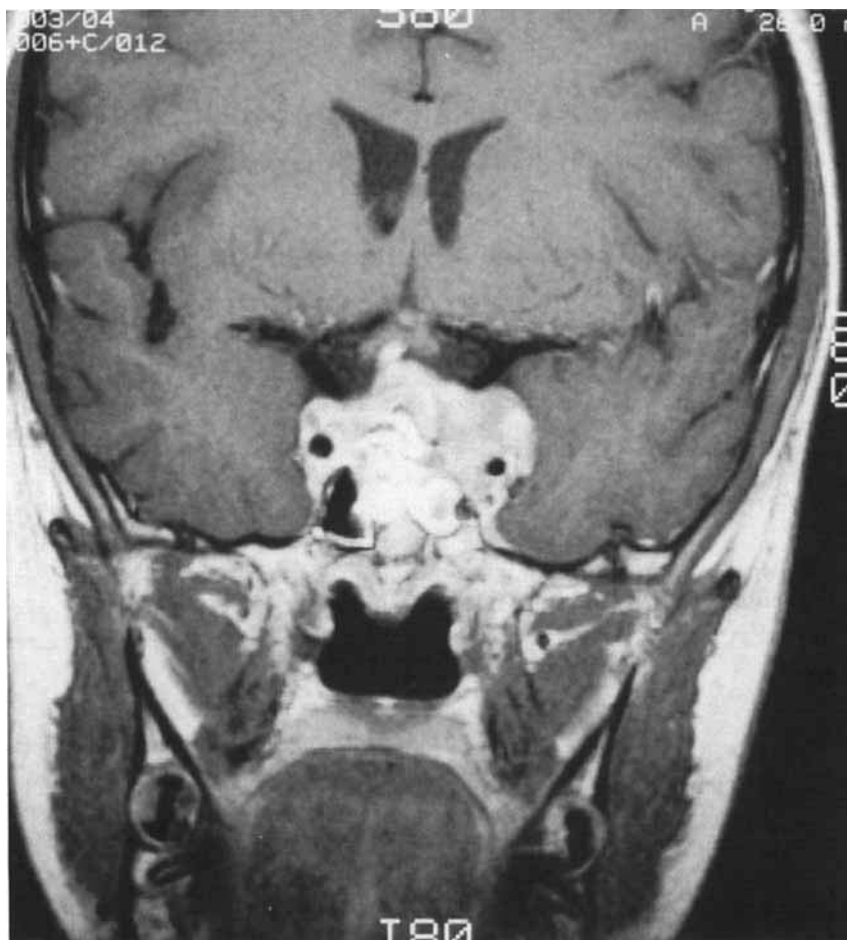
Magnetic resonance image demonstrating a large mixed iso- and hyper-intense (by T1 weighted signal) intrasellar lesion extending into the suprasellar cistern.
